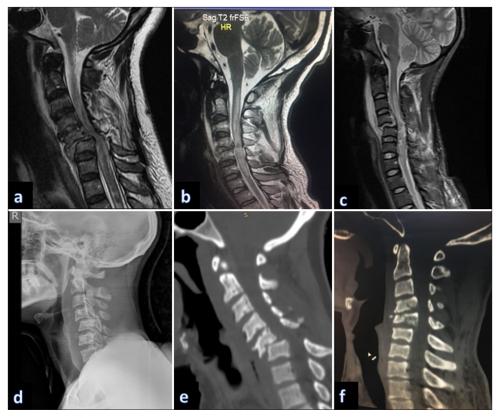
(a-f) Preoperative images of patients with cervical spine injuries. (a-c) Cervical spine MRI showing severe cervical cord injuries with ascending edema up to C1. (d) Cervical spine X-ray showing C4/5 anterolisthesis and bilateral locked facet. (e) CT scan shows C5 vertebra body fracture with >50% anterolisthesis and a bilateral locked facet (not shown in the image). (f) CT scan showing C4 and C5 vertebral body fractures with posterior element injuries.
